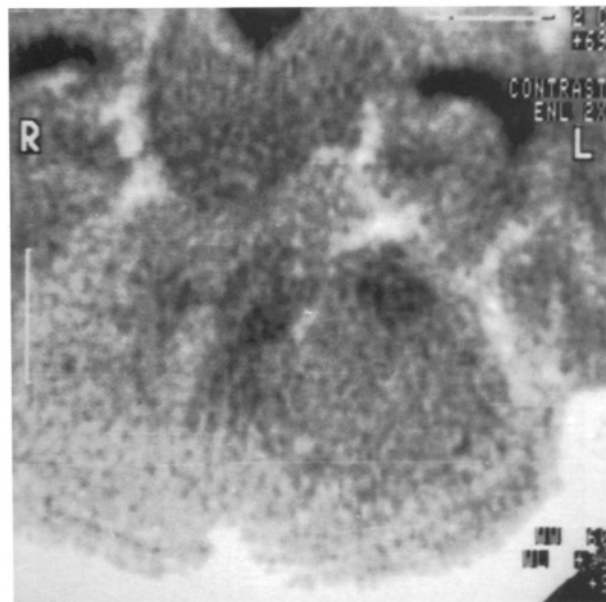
Preoperative CT shows a hypodense mass lesion in the left cerebellar hemisphere leading to the distortion of the 4th ventricle and resulting in the hydrocephalus and the ventromedial part of the lesion a dilated vascular structure.
